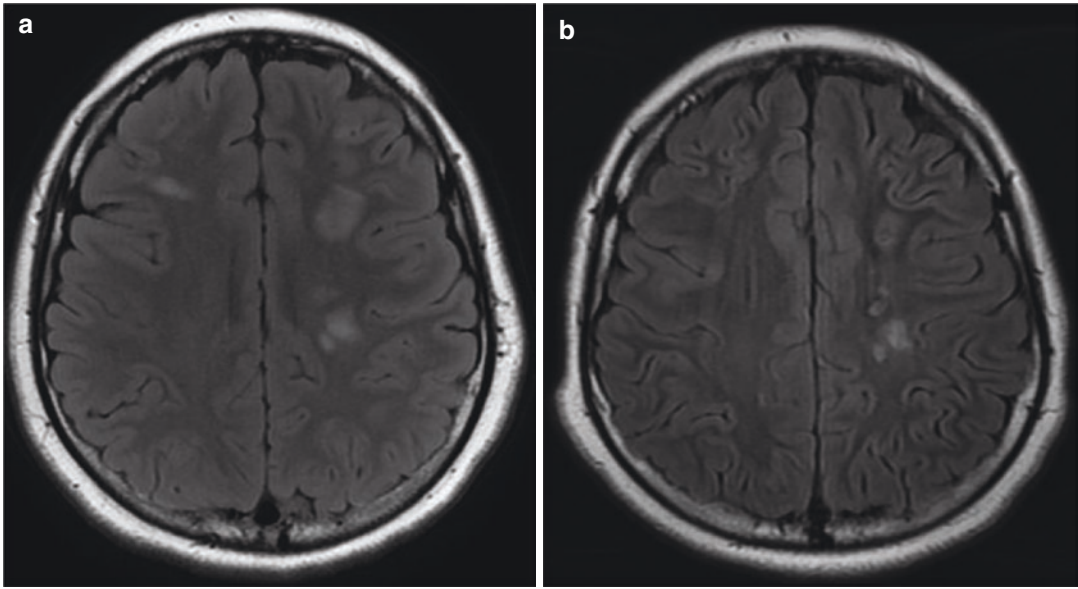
Magnetic resonance imaging (MRI) of brain in T2 and fluid-attenuated inversion recovery (FLAIR) sequence reported multiple hyperintense lesions over bilateral frontal area initially (a). The lesion regressed after 6 weeks (b)
